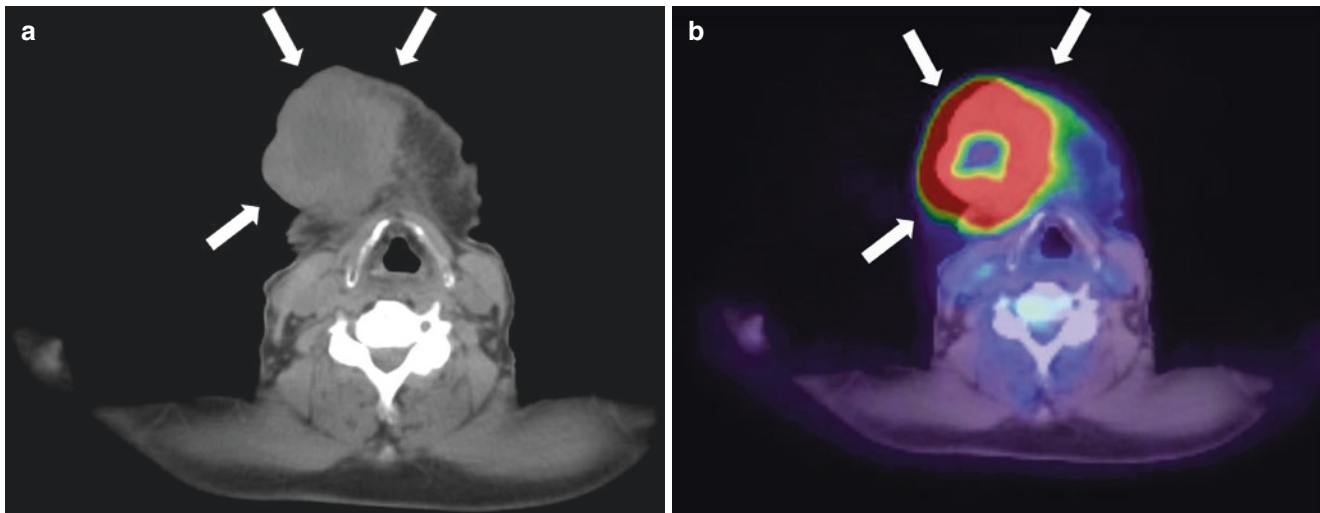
A 72-year-old man with squamous cell carcinoma on the mandibular bone (a, arrows). Ring-shaped tracer accumulation can be seen on the primary site (b, arrows). The measured SUVmax was
